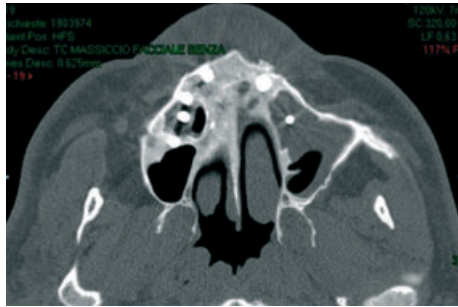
Chronic maxillary sinusitis of dental origin in axial CT scan sustained by endo-antral dental implant.
